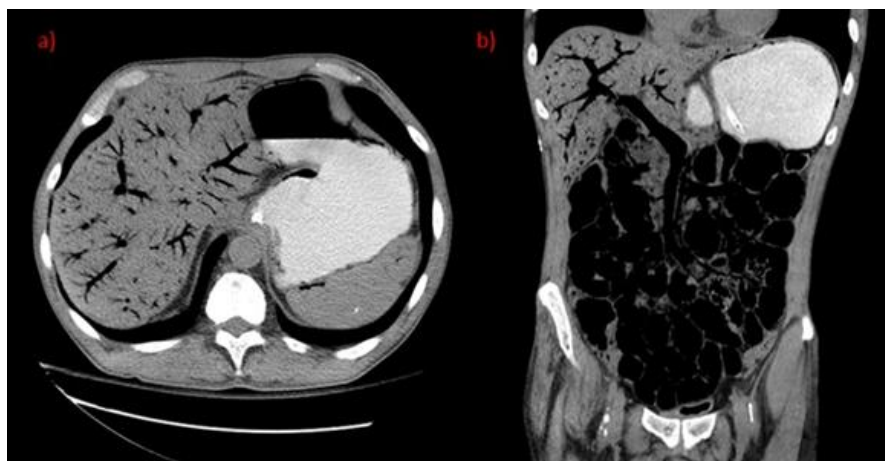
a)CT scan of the abdomen (axial cut) showing extensive intrahepatic portal venous air, air within the gastric wall b) CT scan of the abdomen (coronal cut) showing extra hepatic portal & mesenteric venous air and pneumatosis intestinalis
